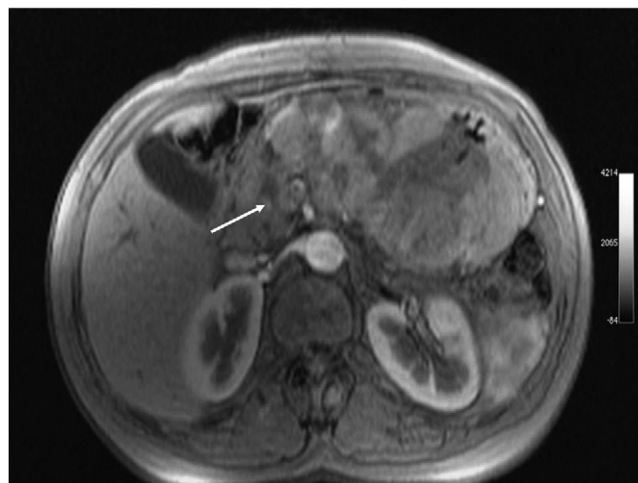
Magnetic resonance imaging (MRI), transverse section, shows the presence of bulging tissue in Wirsung's canal.
